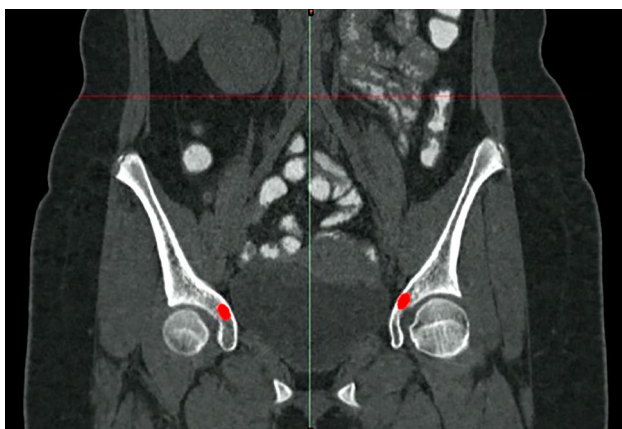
Coronal CT view demonstrating the posteroanterior orientation of the virtual 6.5-mm transcolumbar magic screw trajectory: The screw is inserted from the midpoint of the greater sciatic notch and advances anteriorly along an intraosseous pathway toward the anterior pubic ramus. The trajectory remains fully embedded within the osseous corridor without acetabular joint penetration. The red highlighted area represents the coronal projection of the screw pathway.
